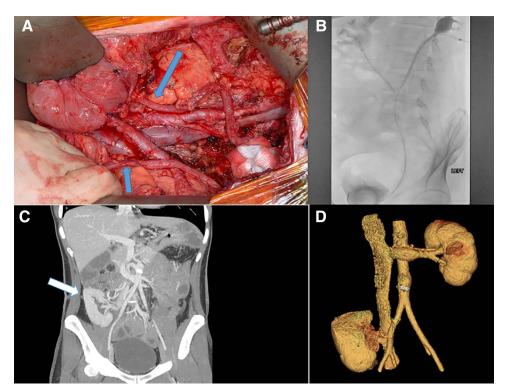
Surgical options when faced with ureteric encroachment in desmoid disease. A, Extensive dissection of the desmoid disease off the ureters (blue arrows). B, Antegrade pyelogram showing a status after a distal right ureteric resection and uretero-ureteral anastomosis due to encasement in the desmoid disease. Note the bilateral DJ stent placement. C, Right renal autotransplant in a case where remnant ureter reimplantation was not possible. D, CT reconstruction of the autotransplant case.
